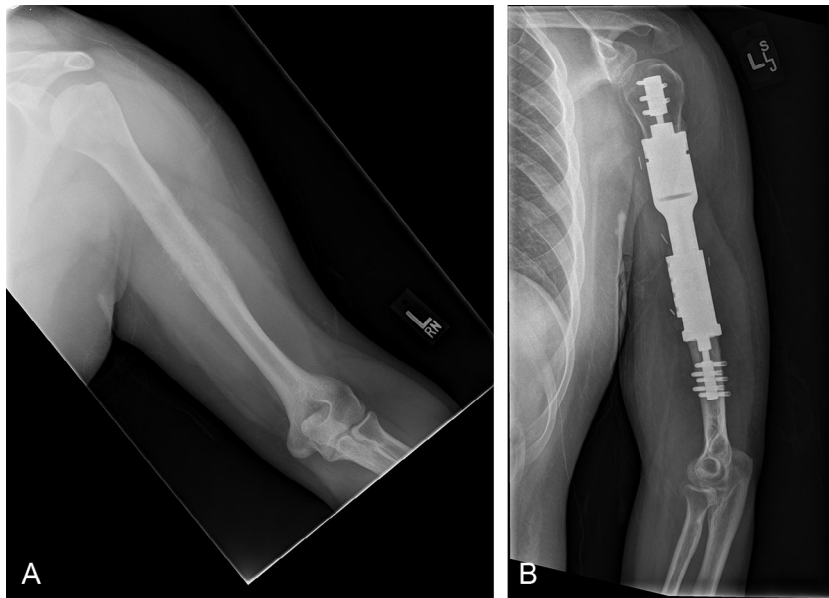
(A) A 22-year-old man with stage IIB Ewing sarcoma of his humerus underwent radical resection. Because of the limited remaining bone stock, an intercalary prosthesis with Compress (Zimmer Biomet, Warsaw, IN, USA) was implanted. (B) Postoperative radiographs at 41 months reveal a stable reconstruction.
